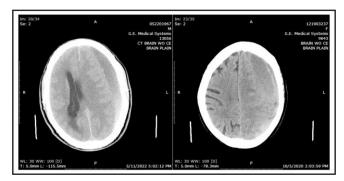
CT of Left-Sided Hematoma (scan included with patient's permission).
